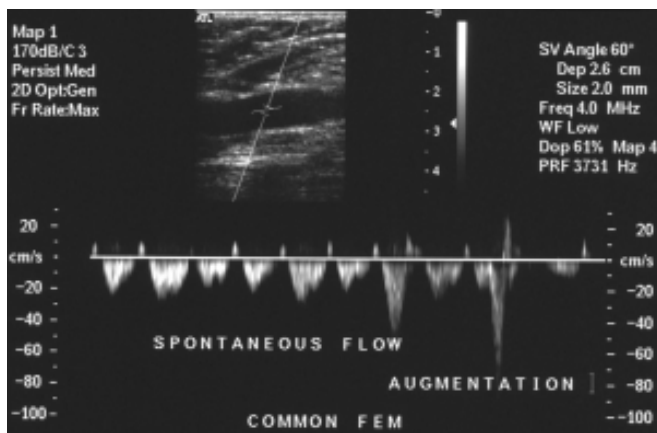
CFV, PW Doppler signal depicting spontaneous flow and brisk flow with augmentation.
